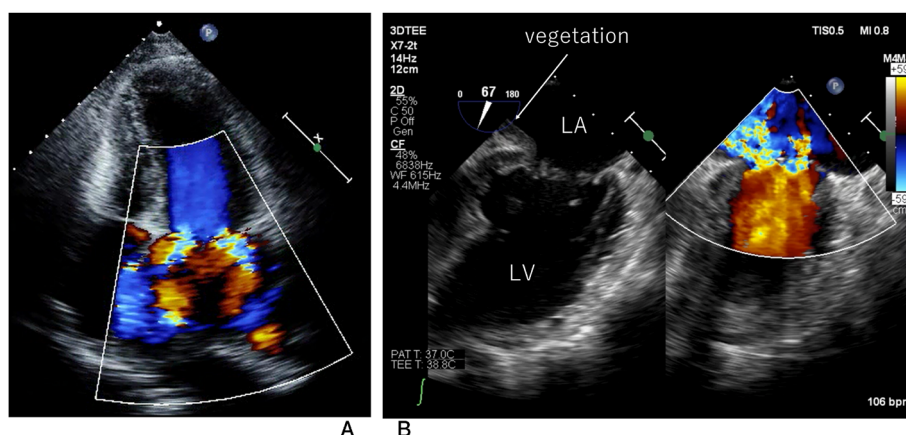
(A) Transthoracic echocardiography shows left atrium dilatation, mitral valvular anterior leaflet prolapse, and severe mitral regurgitation. (B) Transesophageal echocardiography demonstrates isoechoic vegetations (white arrow) at the atrial septum, where the regurgitant jet impacts. LA, left atrium; LV, left ventricle.
